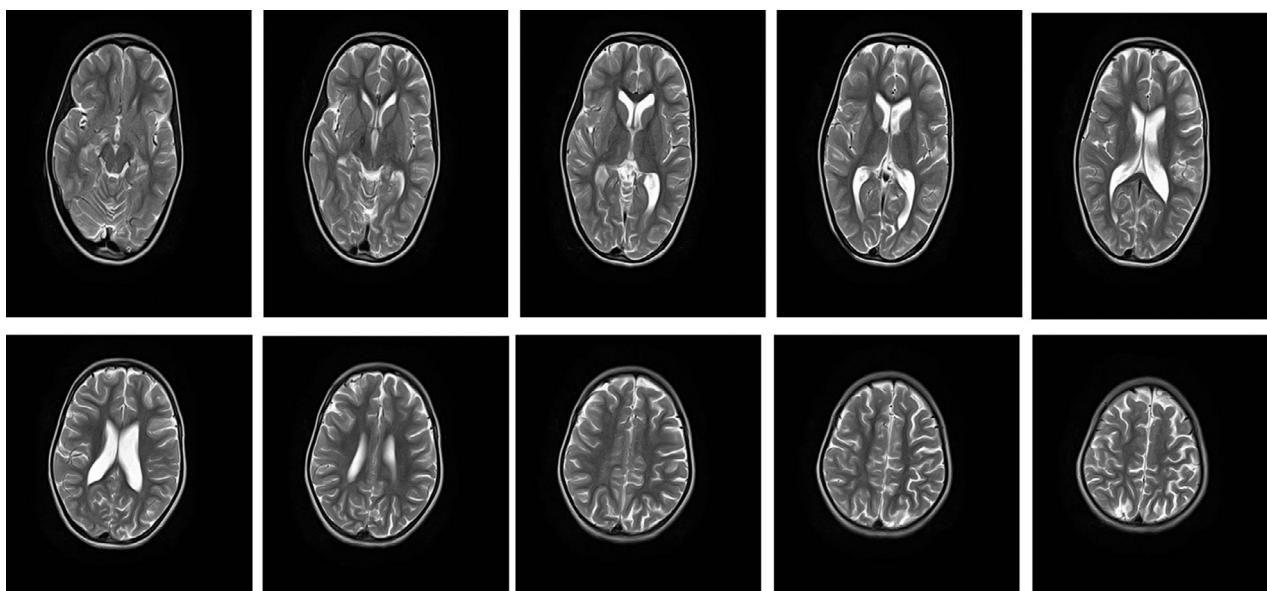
MRI brain showing normal findings, no abnormal density.
